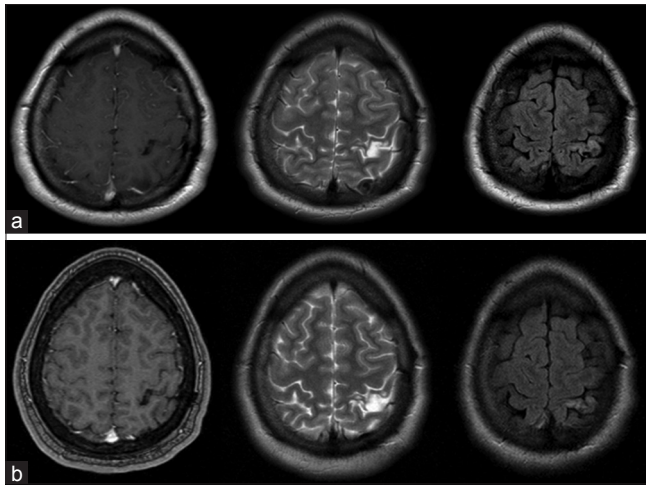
(a and b) T1 + contrast (left), T2 (centre) and FLAIR (right) MR images. Top row (MRI 2008) demonstrates area of T2/FLAIR high signal with no contrast enhancement in the left post central gyrus. Subsequently unchanged over 5 years of follow-up, here compared to MR images from 2013 (bottom row)
